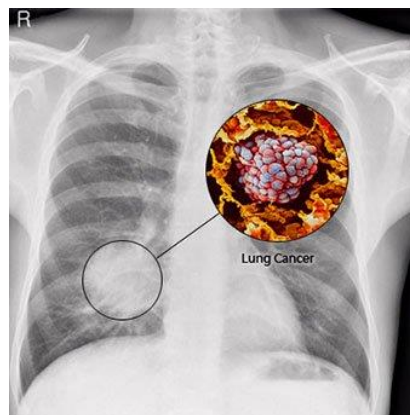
Lung cancer X-ray with callout showing close-up of tumor
